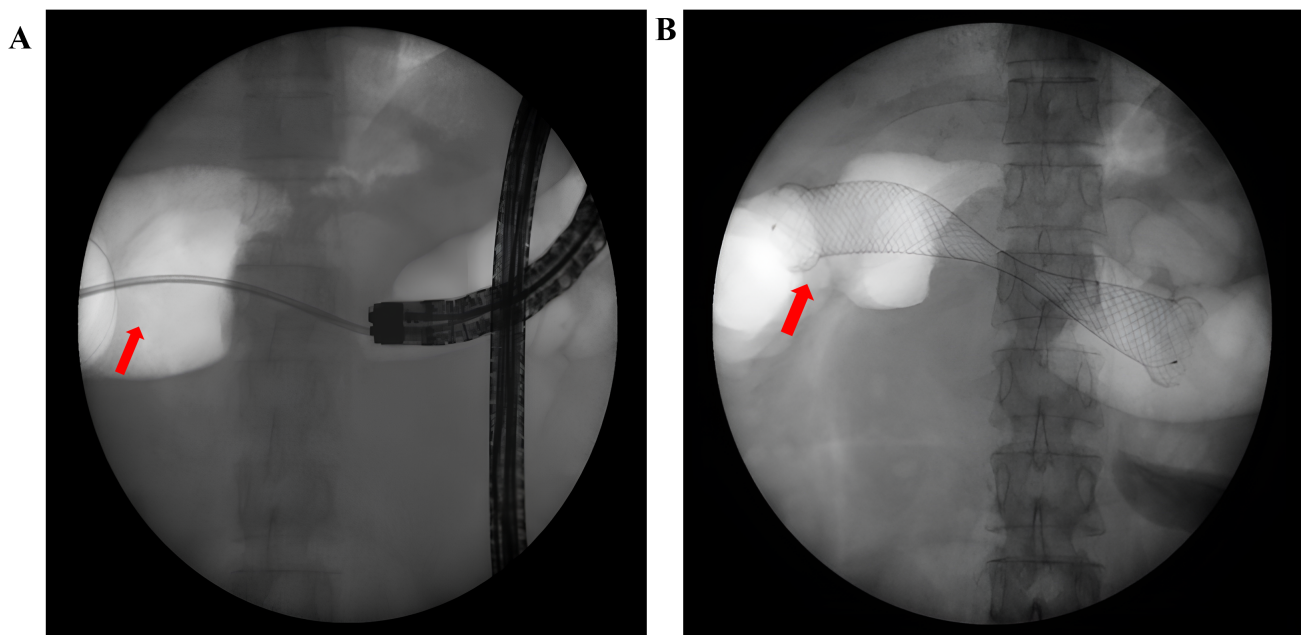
Process of X-ray-guided colonic stent placement under endoscopy for treating CRC with acute intestinal obstruction. (A) The guidewire passing through the narrowed intestinal segment before stent placement. The arrow indicates the guidewire. (B) A follow-up X-ray after stent placement, demonstrating the proper positioning of the stent. The arrow indicates the stent. CRC, colorectal cancer.
